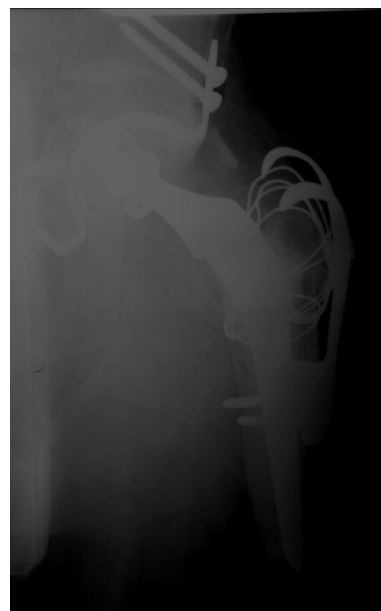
Immediate postoperative radiograph of the revised left hip.
